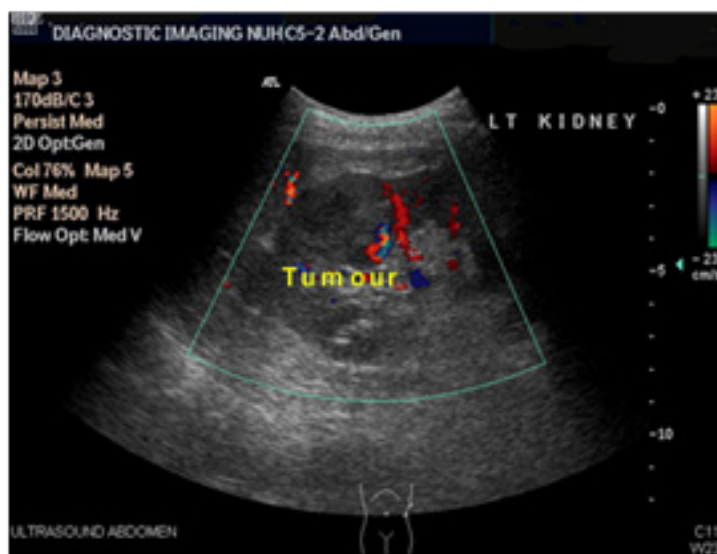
A kidney tumour depicted in both images, on the left is a CT scan and on the right is an ultrasound, adapted from C.C. Min, 2013. It can be observed that the CT scan provides an image with a higher contrast and resolution compared to the ultrasound.
